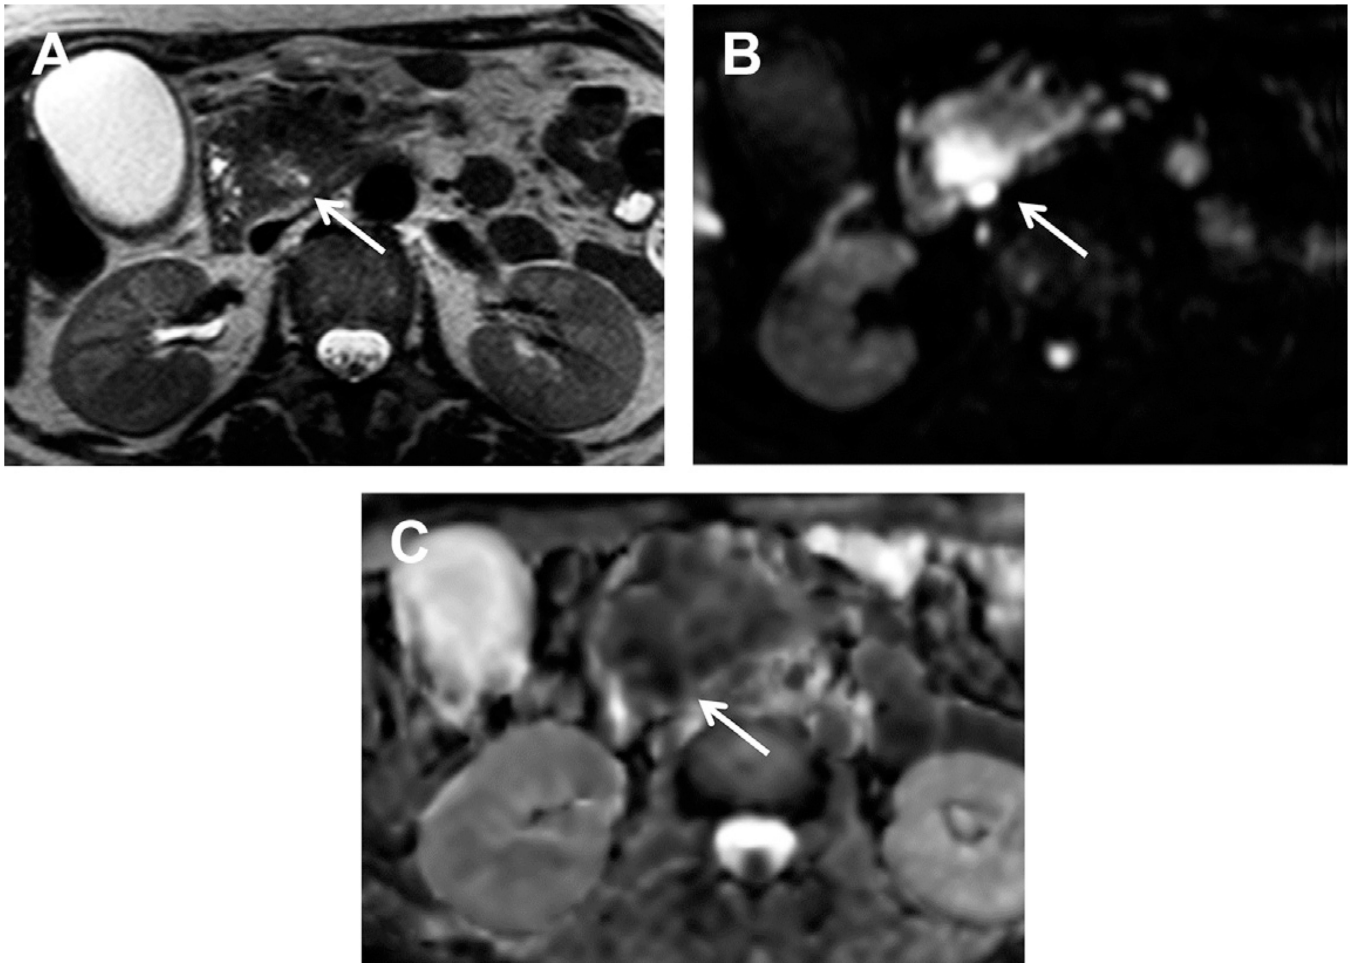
Pancreatic carcinoma (*arrows*) with DWI. (A) Axial TSE T2-weighted image shows an ill-defined mass located in the pancreatic head. (B, C) High b-value DWI and corresponding ADC map demonstrate restriction of water motion of the lesion, with low ADC value: $0.9 \times 10^{-3} \text{ mm}^2/\text{s}$.
